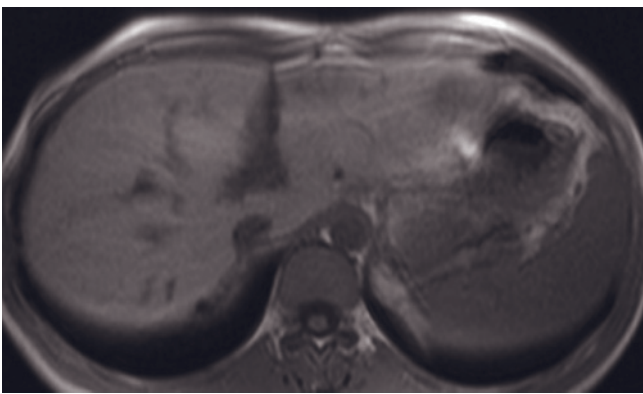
Hypovascular and isovascular HCC. Fat-suppressed T2-weighted SS-ETSE (*a*) and immediate (*b*) and 90-s fat-suppressed (*c*) postgadolinium SGE images. There are two nodular lesions in the top of the liver. The largest one (arrow, *b*) shows low signal intensity on T2-weighted image (*a*) and minimal enhancement on early-phase image (*b*) that decreases over time (*c*), compatible with hypovascular HCC. Nearby the hypovascular HCC, there is a smaller lesion that shows high signal intensity on T2-weighted image (*a*) and ring and perilesional enhancement on early-phase image (*b*) that becomes more conspicuous on late-phase image (*c*), consistent with metastasis from the HCC.
